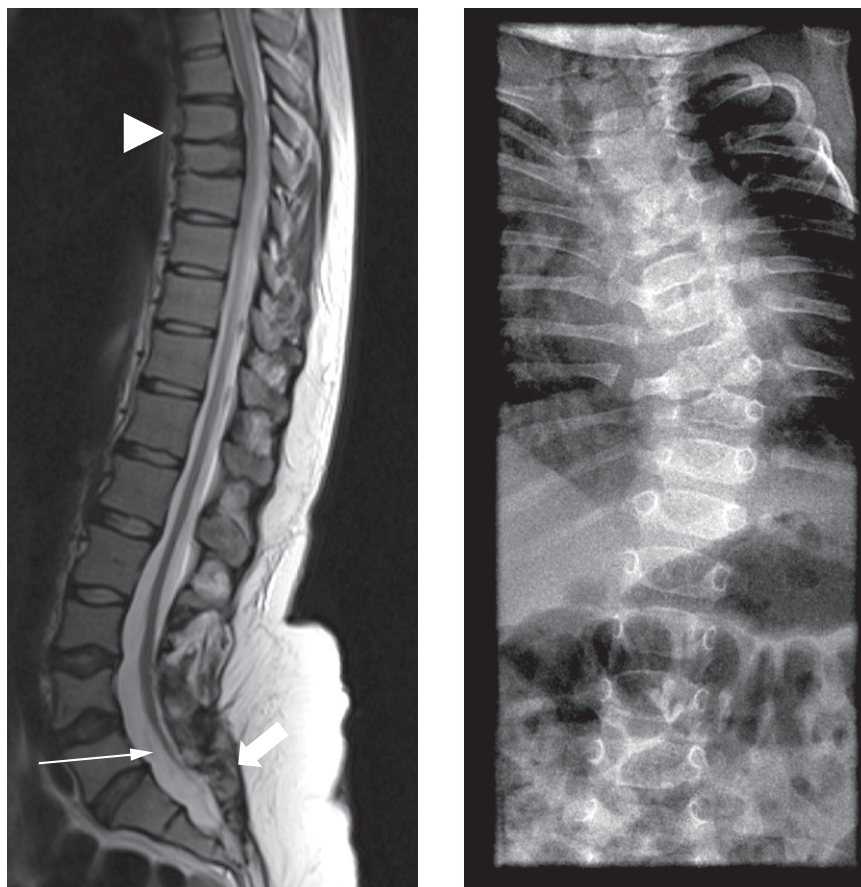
Congenital spinal anomalies. (a) Sagittal T2-weighted MRI showing the conus is located abnormally low at approximately L5/S1 (long arrow) with incomplete formation of the low lumbosacral posterior elements (wide arrow). There is also a segmentation anomaly at T7–T9 with poorly formed intervertebral discs (arrowhead). (b) Frontal radiograph of an infant showing an early scoliosis due to a left hemivertebra at T8 – note the number of ribs compared to pedicles.
